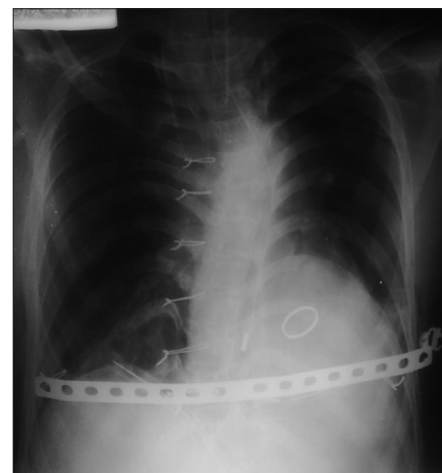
Chest X-ray with dynamic compression plate supporting lower xiphisternum
